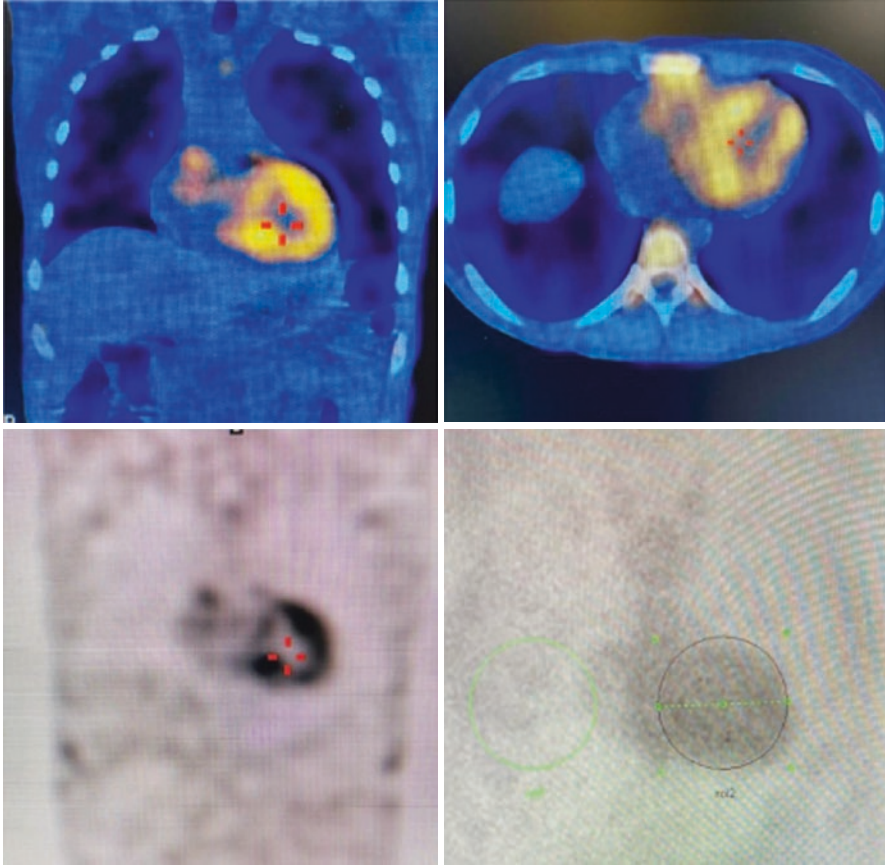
Myocardial scintigraphy with technetium-99 m-labeled pyrophosphate. Increased radiotracer concentration in the projection area of the heart against the costal margin, corresponding to score 3 [10]
